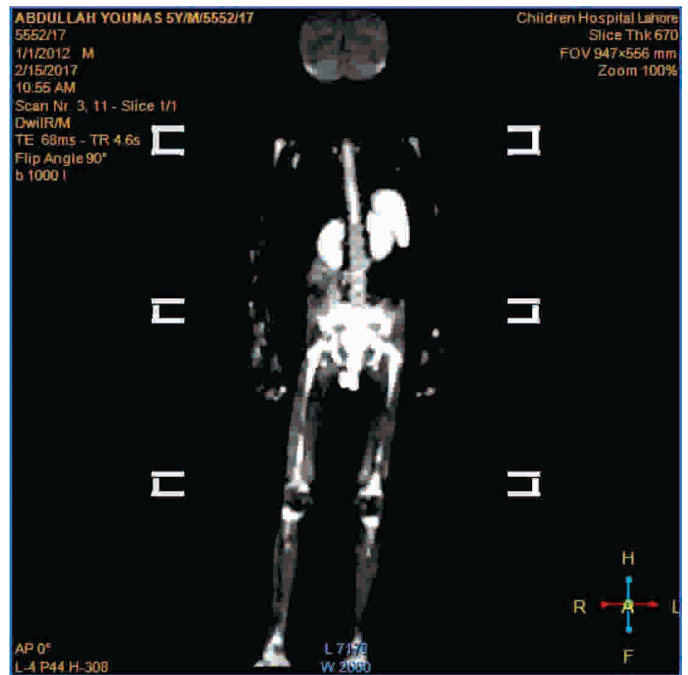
Same Patient Post Chemotherapy DW Whole Body MRI Shows no Left Sided Cervical and Supra-Clavicular Lymphadenopathy Suggesting Complete Resolution
